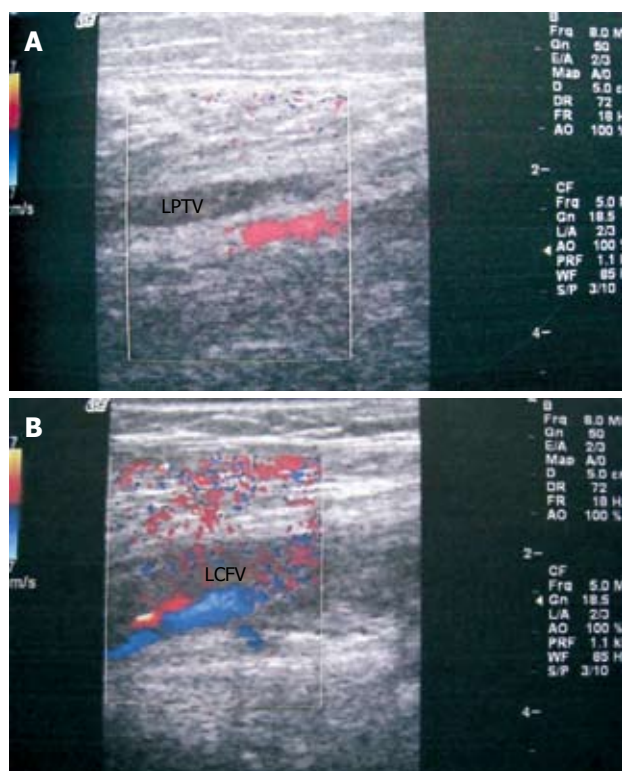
B type ultrasound (A and B) showed the left leg DVT.
